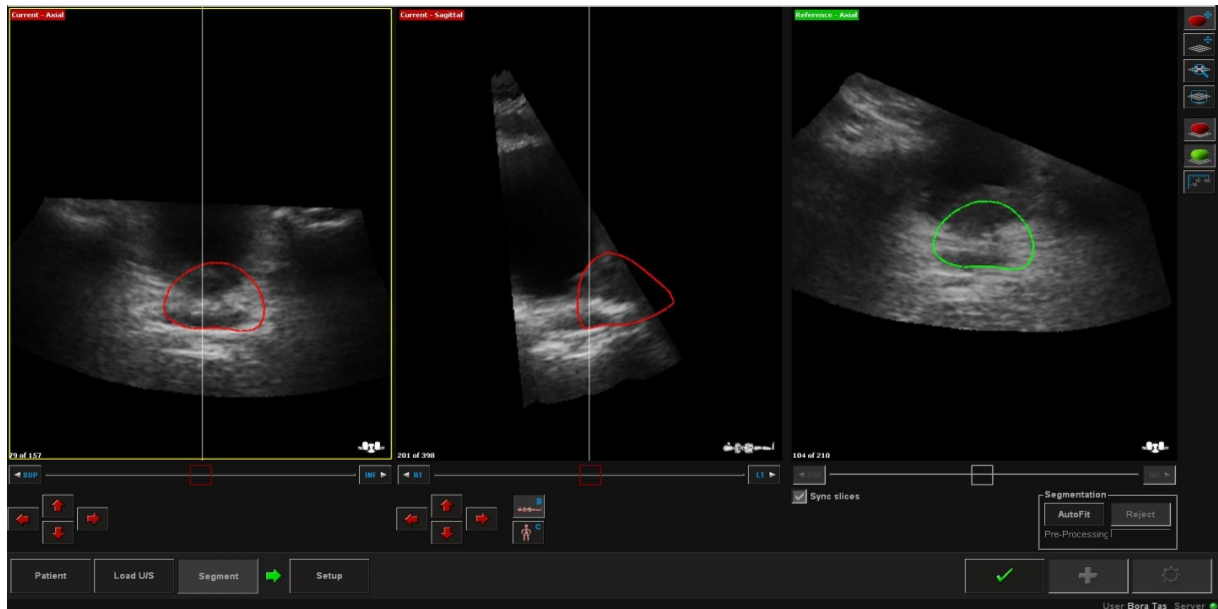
Prostate ultrasound scan by Transabdominal probe
